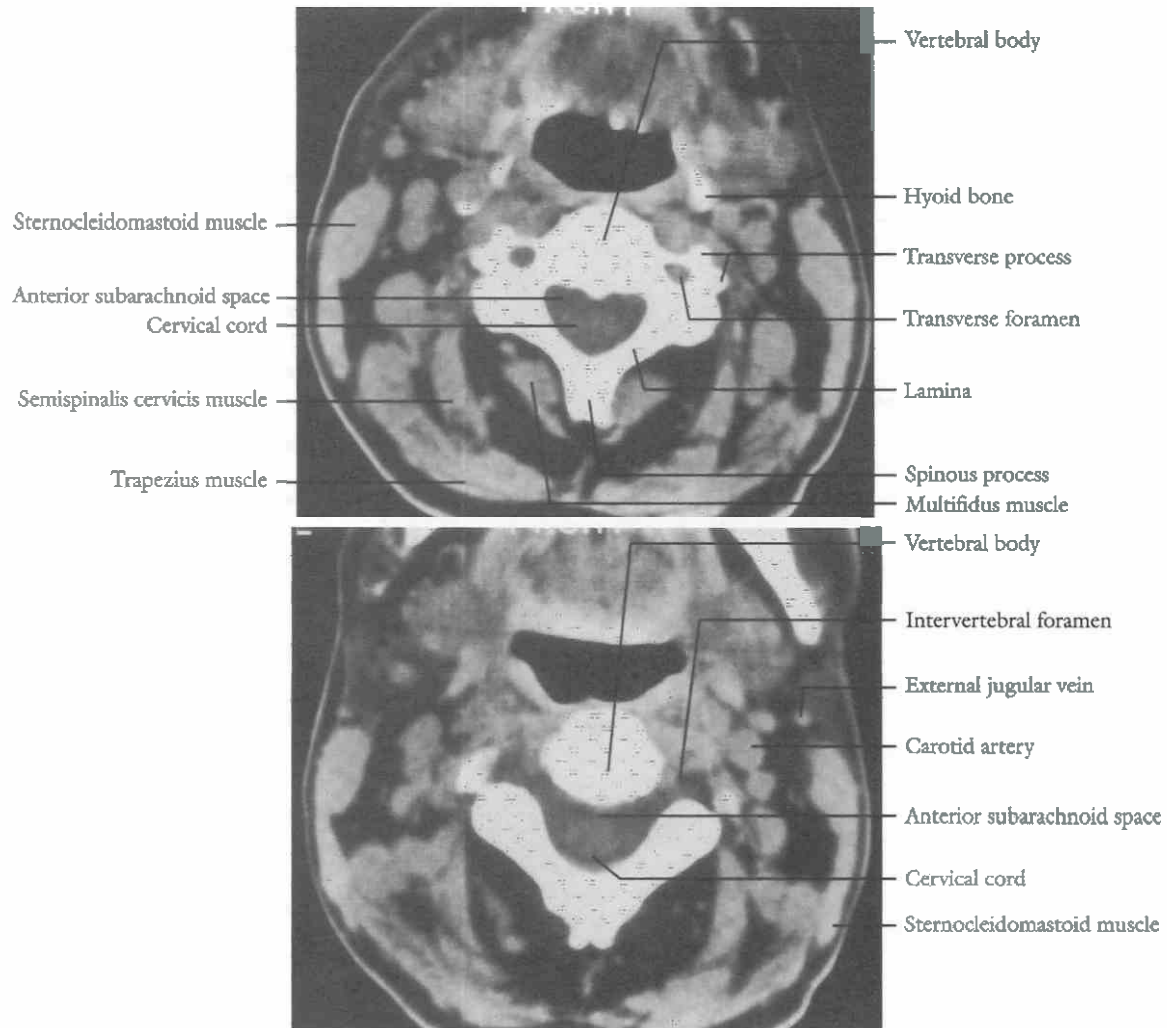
Top*, Axial CT scan through a cervical vertebral body, showing the transverse foramina for passage of the vertebral arteries. *Bottom*, Axial CT scan through the intervertebral foramen in the midcervical region. The large amount of cerebrospinal fluid in front and back of the cervical cord helps to delineate the cervical cord and the roots.
